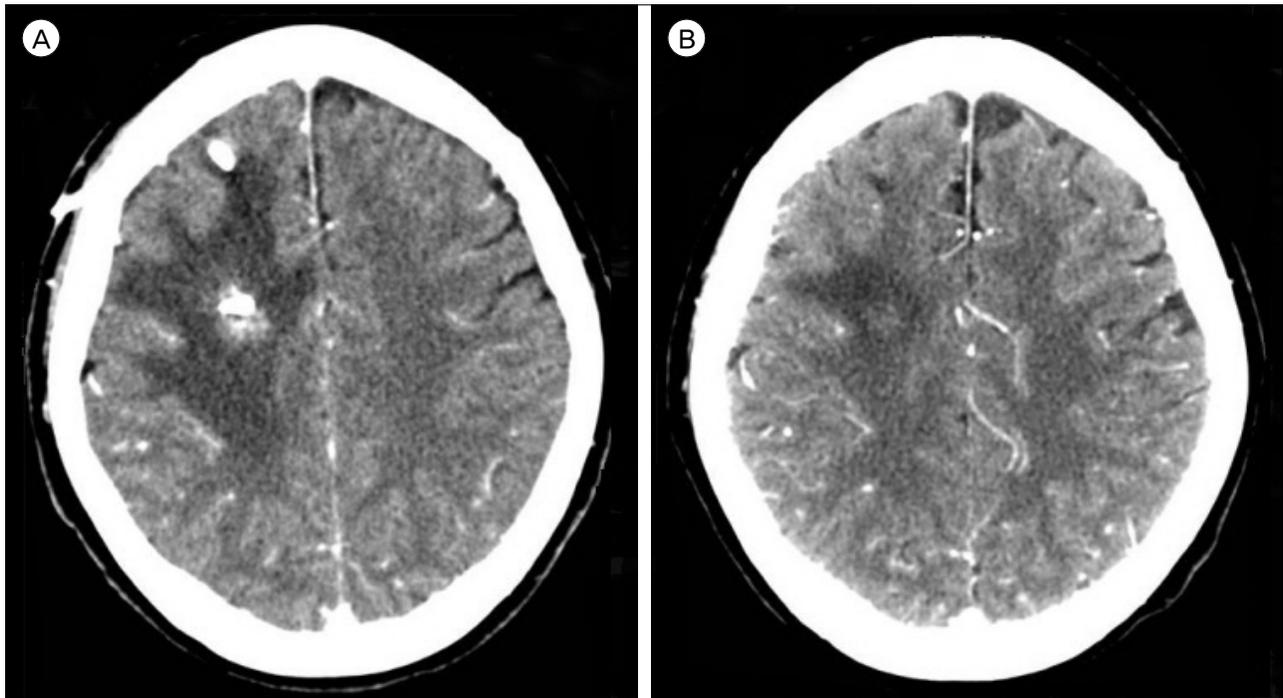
(A) Post-operative contrast enhanced CT images. Two catheters are placed in the ventricle and abscess. Decrease in the size of an abscess pocket in the frontal lobe. (B) Final follow-up contrast enhanced CT images. CT shows only minimal edematous changes on a previous abscess loculated lesion. CT = computed tomography.
